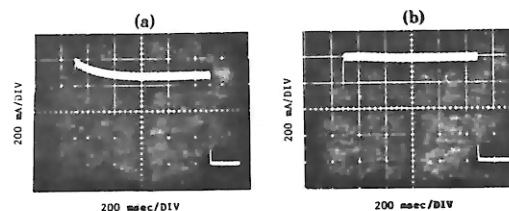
Oscilloscope traces of x-ray tube current vs time for large focal spot of GE Maxiray 75, 1.0/2.0 mm focus, Model No. 11DB6A1 x-ray tube at 800 mA and 60 kVp (3 ϕ): (a) without correcting for cooling effect of electrons evaporating from the filament; (b) correcting for cooling effect.
